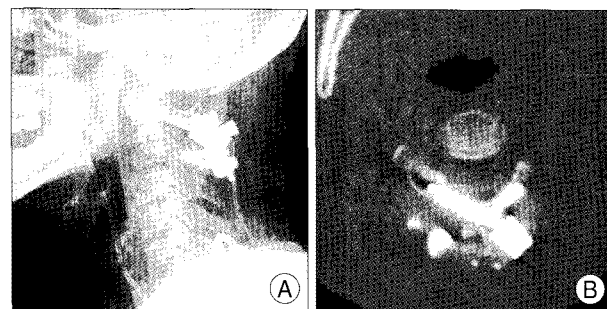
A : Lateral radiograph showing C1-2 stabilization with C1 pedicle screws and C2 translamina screws. B : Axial computed tomography scan showing the C2 lamina with crossing intralaminar screws.
